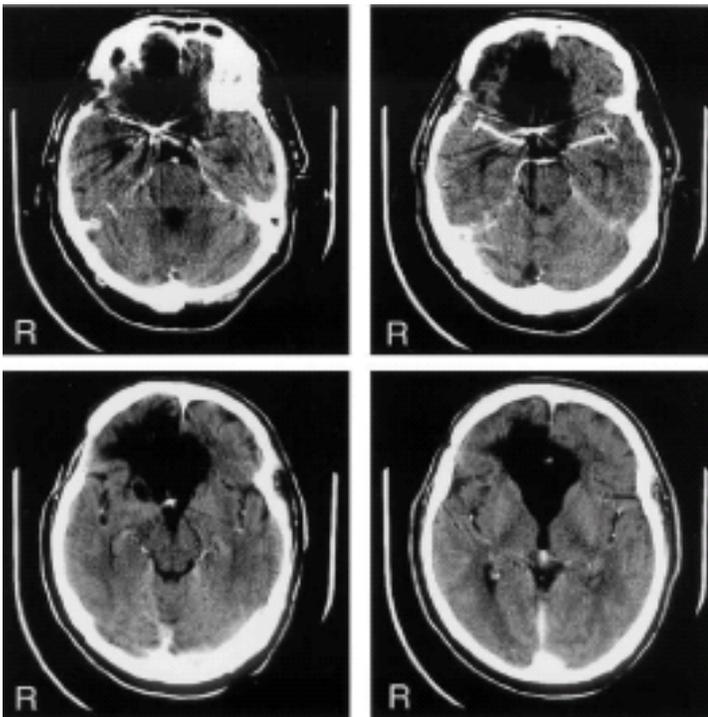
CT scan of J.S.'s brain
